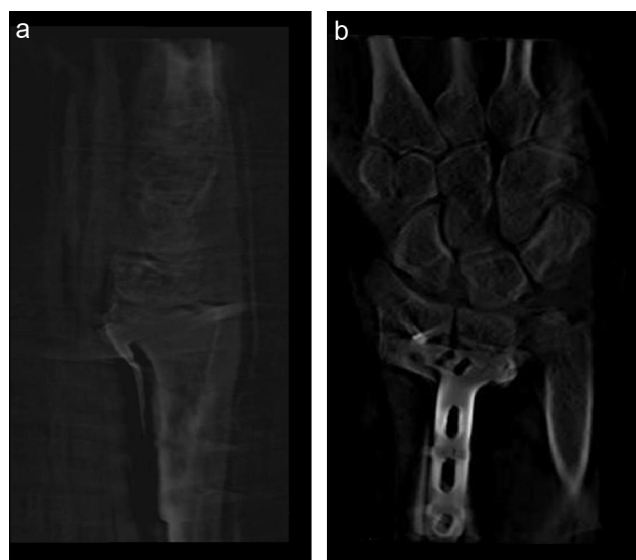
a and b: two reconstructed image examples of a 3D DVT dataset, showing LCP osteosynthesis at the distal radius. In opposite to 3D-fluoroscopy and X-ray, the image quality of the DVT datasets, that was acquired with 50–100 μ Sv, was rated “low” due to the beam hardening artefacts as well as low contrast of the joint surface in the reconstructed images (Fig. 3a). However, the 3D DVT showed a higher sensitivity for the detection of intraarticular screw cutting out than X-ray and 3D fluoroscopy.
